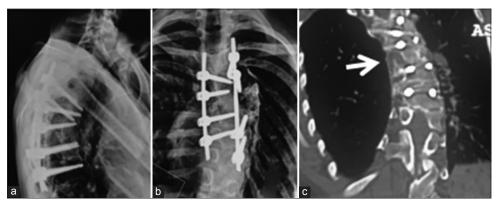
Post-OP imaging, (a) lateral view normal kyphosis is obtained, (b) AP radiographs showing the correction of scoliosis, (c) reformatted coronal CT, note all screws are in ideal place and a tricortical iliac graft (white arrow).
